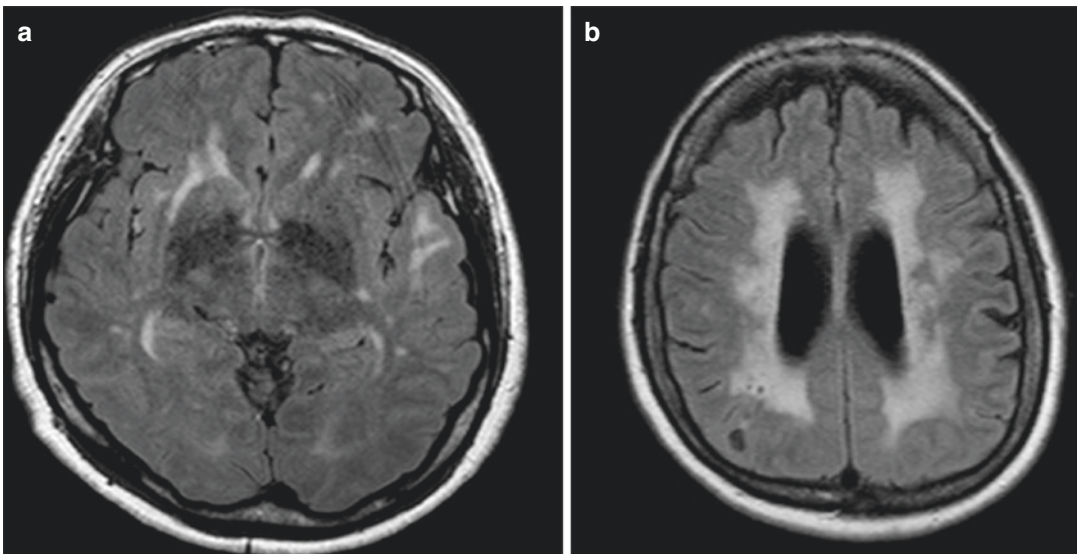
Typical magnetic resonance imaging in CADASIL. (a) Hyperintensities in anterior temporal pole and external capsule. (b) Severe periventricular white-matter change and microbleeds
